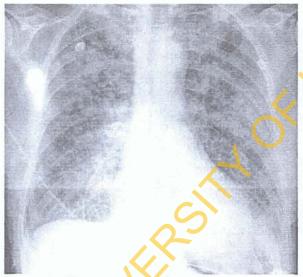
Postero anterior chest radiograph showing the typical cotton wool appearance often associated with pulmonary oedema.
